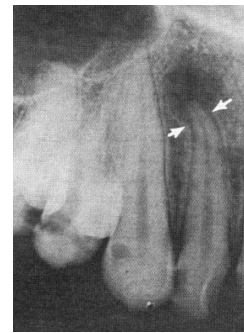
Intraoral periapical radiograph of upper teeth [28].
